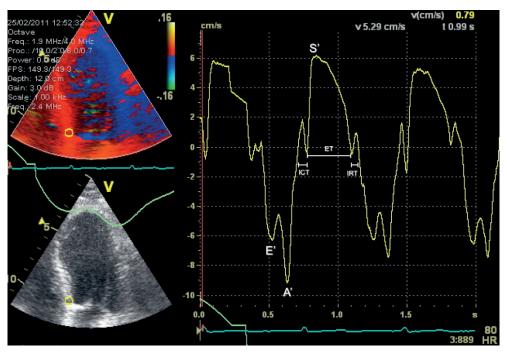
Myocardial velocity-time curve from tissue Doppler recording (TDI) of the medial mitral annulus. MPI is calculated from the time intervals as: MPI = ([ICT + IRT] / ET).
